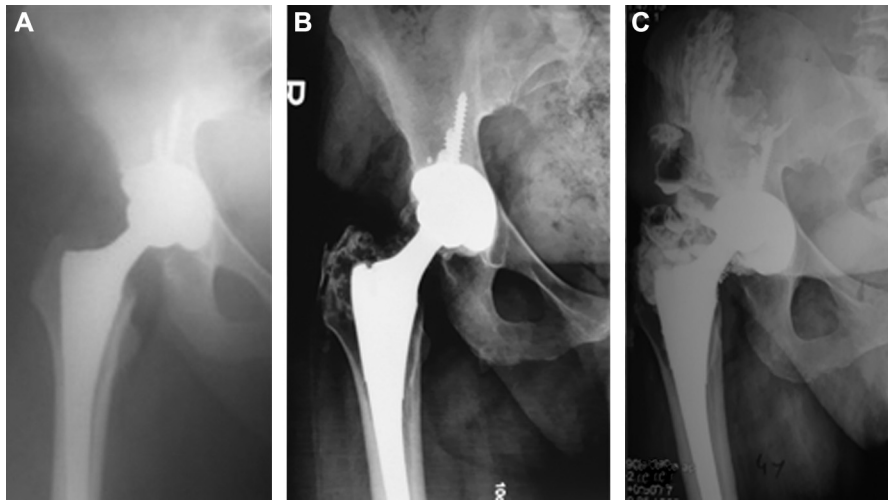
Plain radiographs showing a 52-year-old female patient who underwent right hip arthroplasty. A. Immediate postoperative after the index operation. B. At her fourth year's follow-up showed early metal debris collection in joint and around greater trochanteric area. C. At 4 year 4 months' follow-up taken in our clinic showed metallosis radiates to proximally through gluteal muscles. Eccentric position of the head in the cup was also observed.
